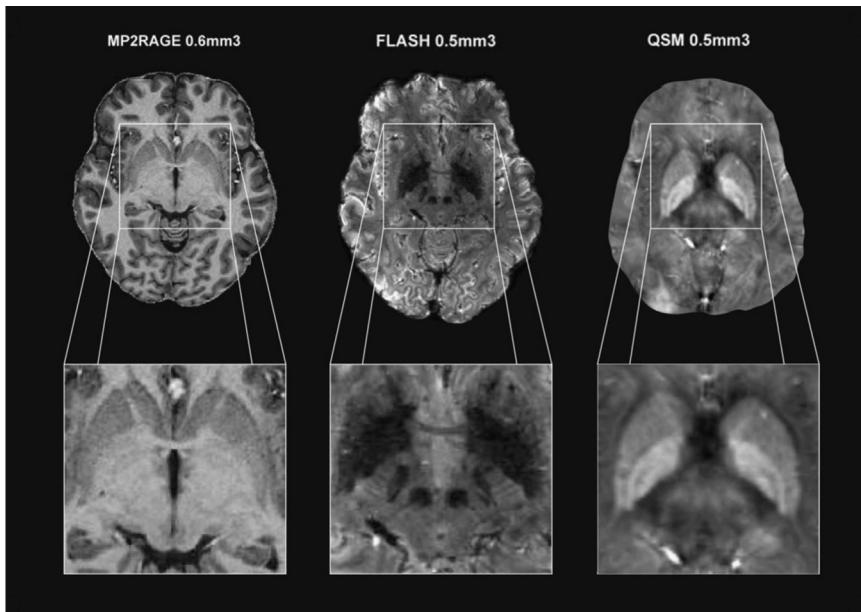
MRI scan sequences used for creating probabilistic atlas maps. Left: T1-weighted MP2RAGE sequence; middle: T2*-weighted FLASH sequence; right: QSM. Reprinted from [2], with permission from Elsevier.
